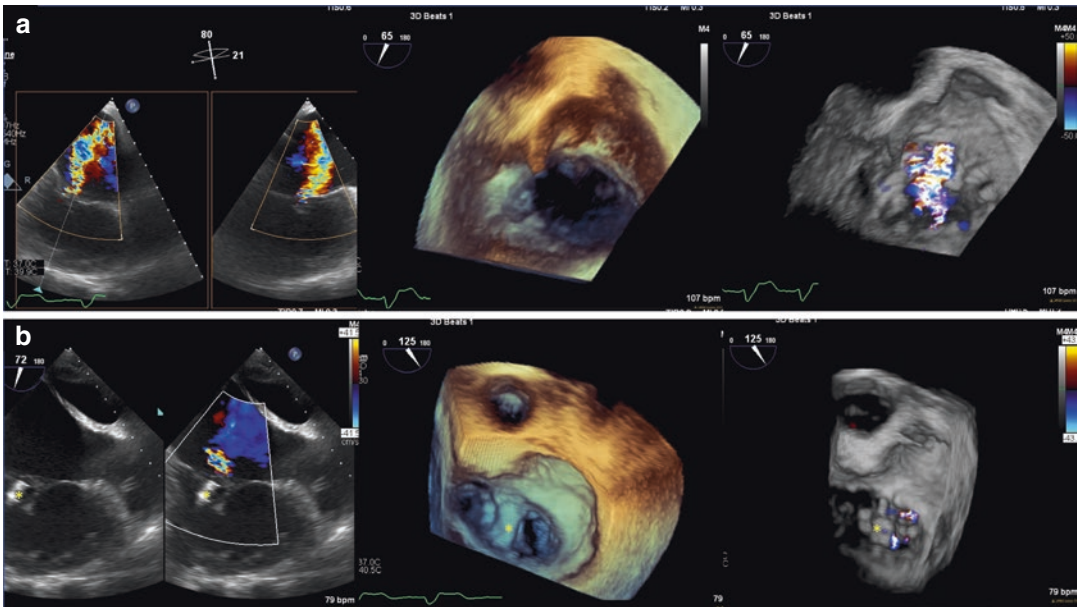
Transcatheter Edge-to-Edge Repair using a Mitraclip in a Patient with Adult Congenital Heart Disease (Transesophageal Echocardiography Images). (a) Baseline transesophageal echocardiography (TEE) images of the Mitraclip procedure in a patient with severe common atrioventricular valvular regurgitation and single ventricle physiology. The left pane shows 2-dimensional X-plane color Doppler images of the valve with severe regurgitation. The middle pane is a 3-dimensional TEE
